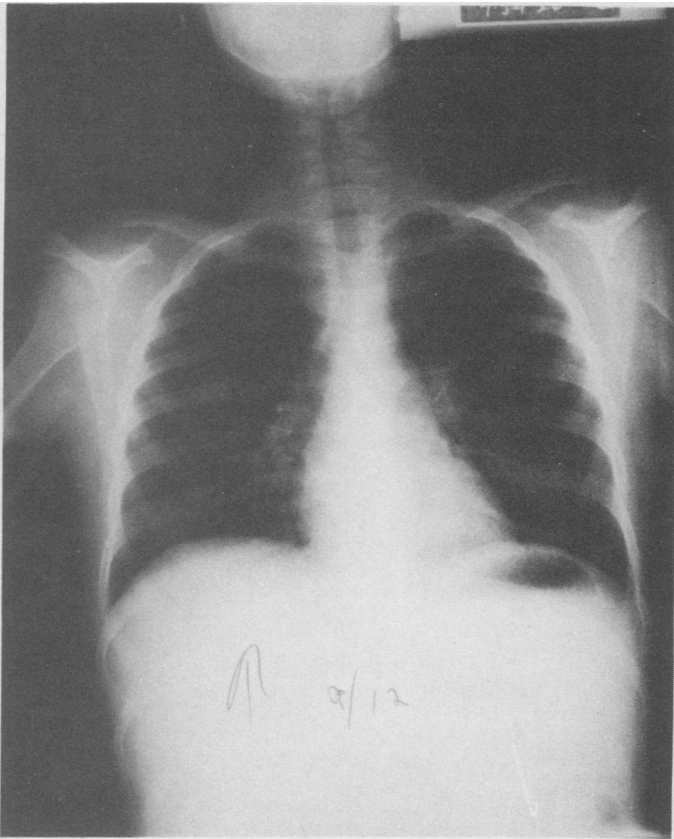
Chest x-ray in patient 7 taken 3 months prior to *Pneumocystis pneumonia*. The patient had *Aspergillus* in her sputum and the typical radiographic signs of an aspergilloma in the right upper lobe.
